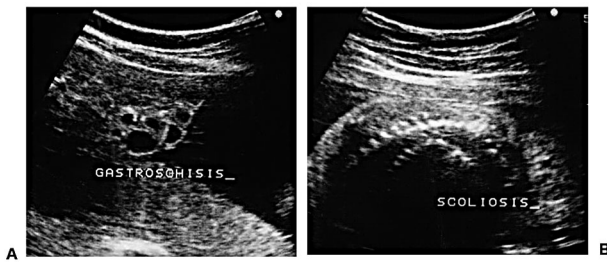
Sonogram of the fetus shows herniated viscera (A) and scoliosis of the spine (B).
